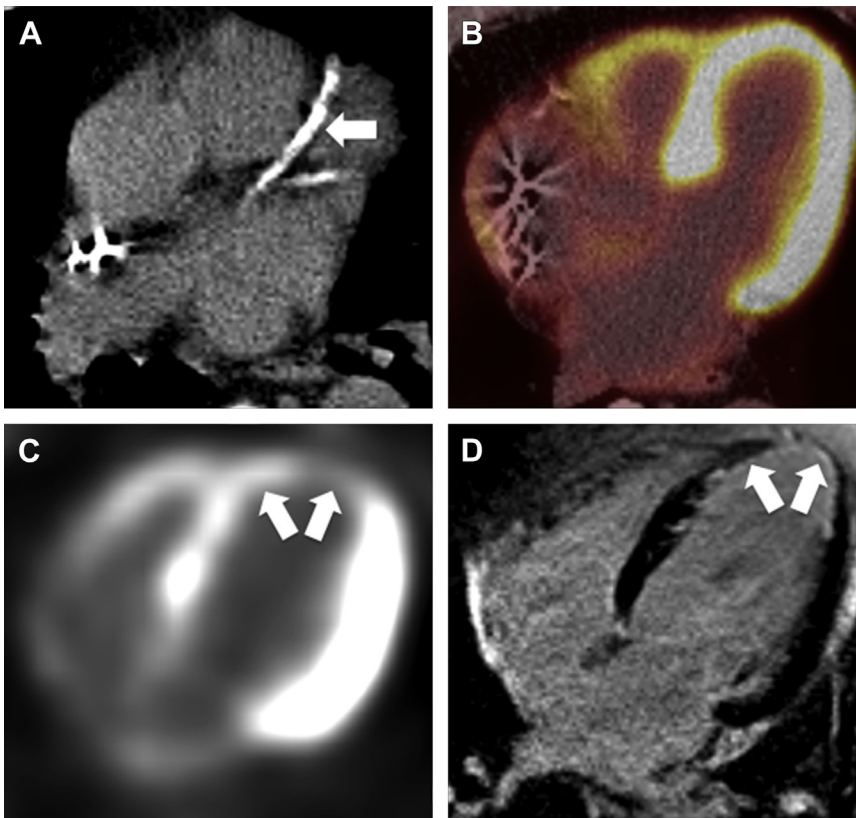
(A) Male patient with severe global LV dysfunction and heavily calcified coronary arteries (*arrow*). 18FDG PET study shows normal metabolic activity throughout the left ventricle (*B*), suggesting myocardial viability. (C) Female patient with decreased tracer uptake in the distal septum and apex (*arrows*) at 18FDG PET with (*D*) matching hyperenhancing scar on LGE imaging.
